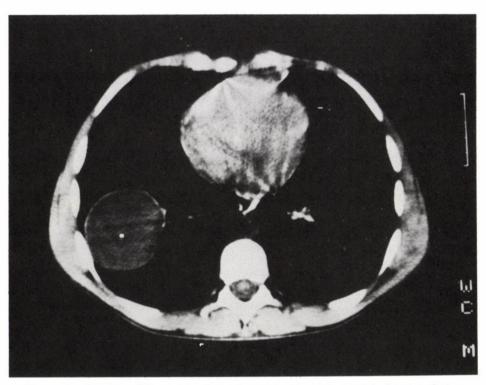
Thorax CT: unruptured cyst in the right lower lobe.
